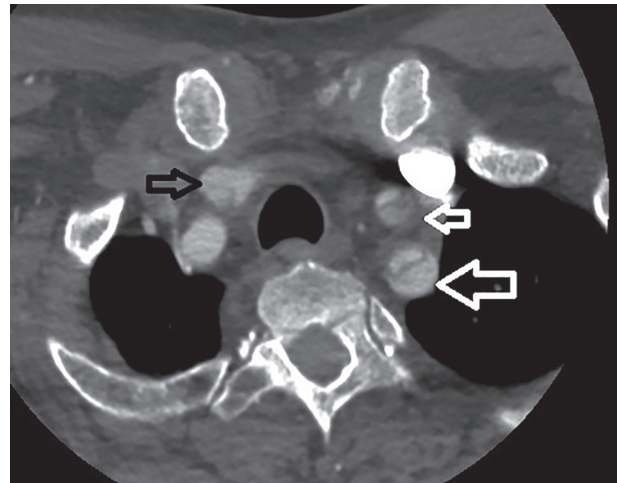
Computed tomography angiography showing aortic dissection from the aortic root, extending into ascending aorta, arch, descending aorta, and into the proximal portion of the right brachiocephalic artery
